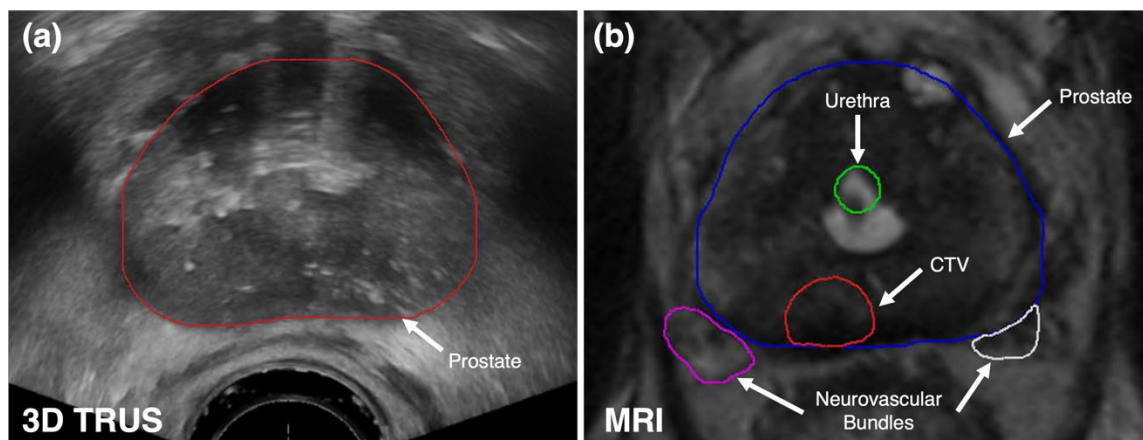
Example (a) three-dimensional transrectal ultrasound image and corresponding prostate contour in the axial plane and (b) axial T2-weighted 1.5T magnetic resonance image with physician-drawn prostate, urethra, clinical target volume (CTV), and neurovascular bundle (NVB) contours.
